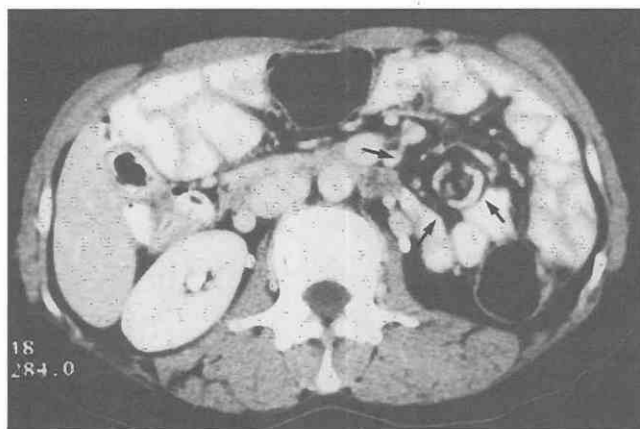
Subtotal gastrectomy with gastrojejunostomy performed for gastric cancer in an asymptomatic patient. The CT scan, obtained for routine follow-up study, shows twisting of the mesenteric vessels ("whirl sign") (arrows). (From Ha HK, Rha SE, Kim JH, et al: CT diagnosis of strangulation in patients with small bowel obstruction: Current status and future direction. *Emerg Radiol* 2:47-55, 2000.)
